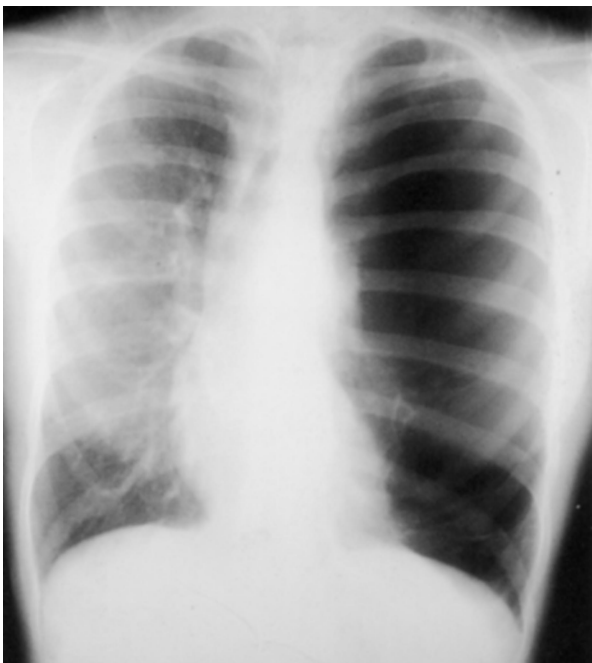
Posterior-anterior chest radiograph revealing hyperlucency of the left lung, with only scant lung markings in the medial aspect of the left apex and hyperexpansion of the left hemithorax, with shift of the mediastinum to the right.
